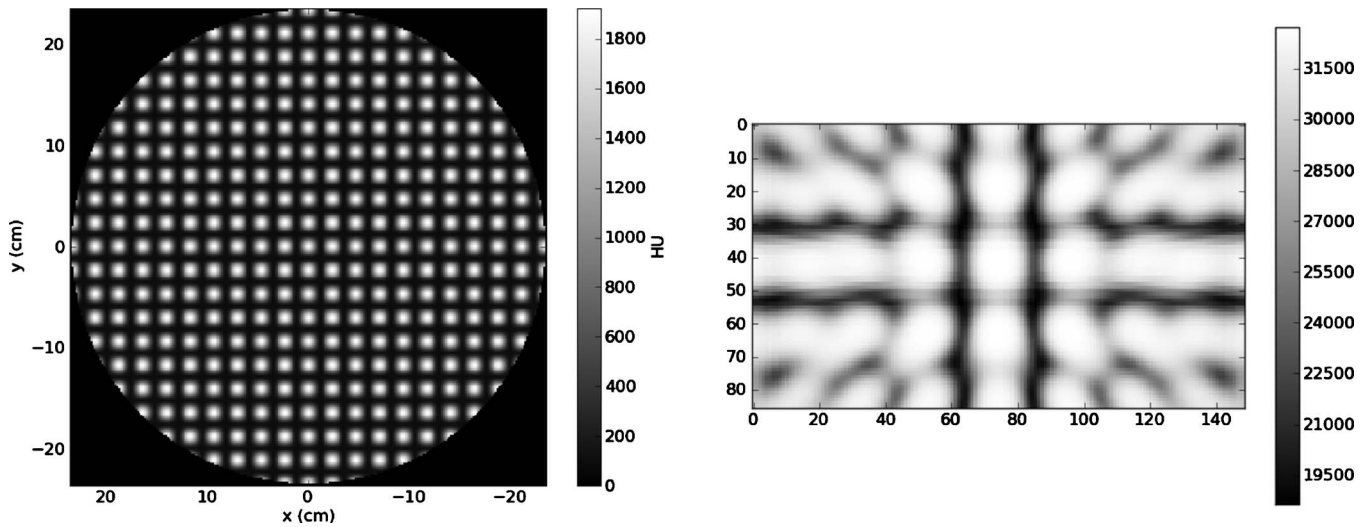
A slice through the spherical CT image (left) and a projection through the CT image (right).
